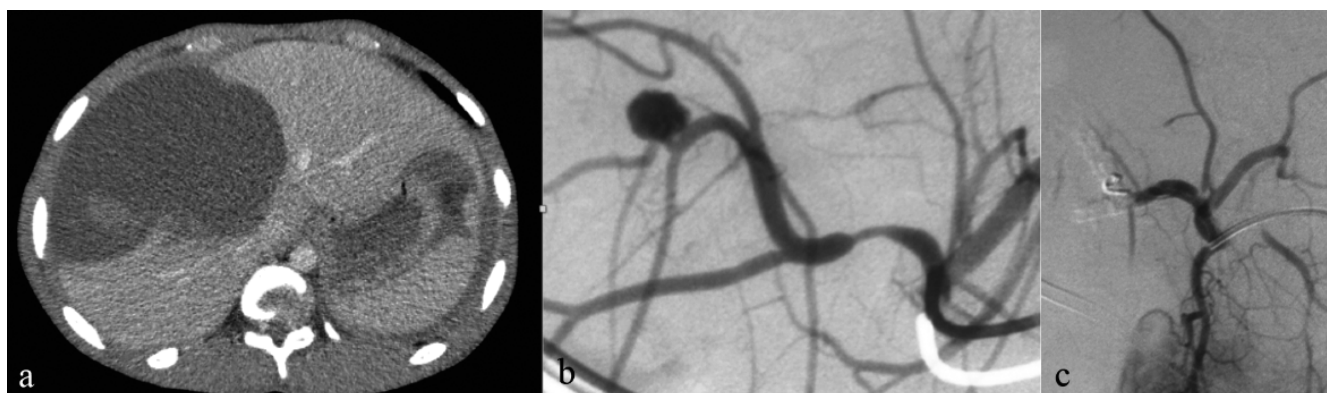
(a) Contrast CT scan showing features suggestive of a large sub-capsular biloma (18 Hounsfield units); (b) pseudo-aneurysm of segmental branch of the right hepatic artery; (c) post-coil angio-embolisation of hepatic artery pseudo-aneurysm.
